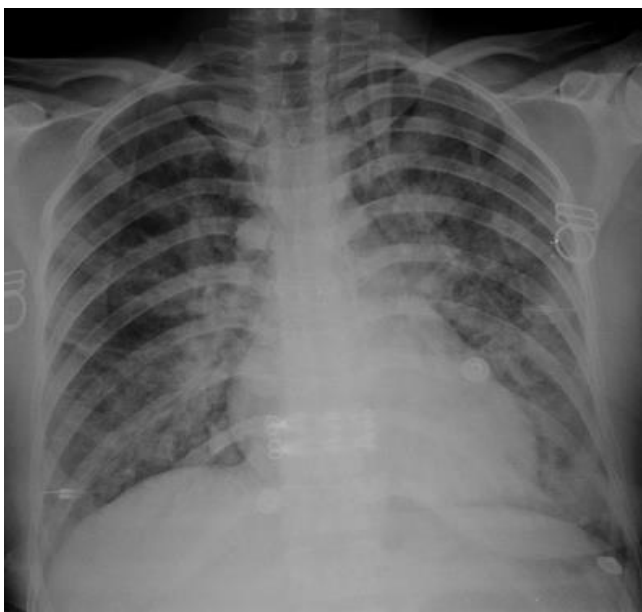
Bilateral patchy infiltrations on chest radiography
